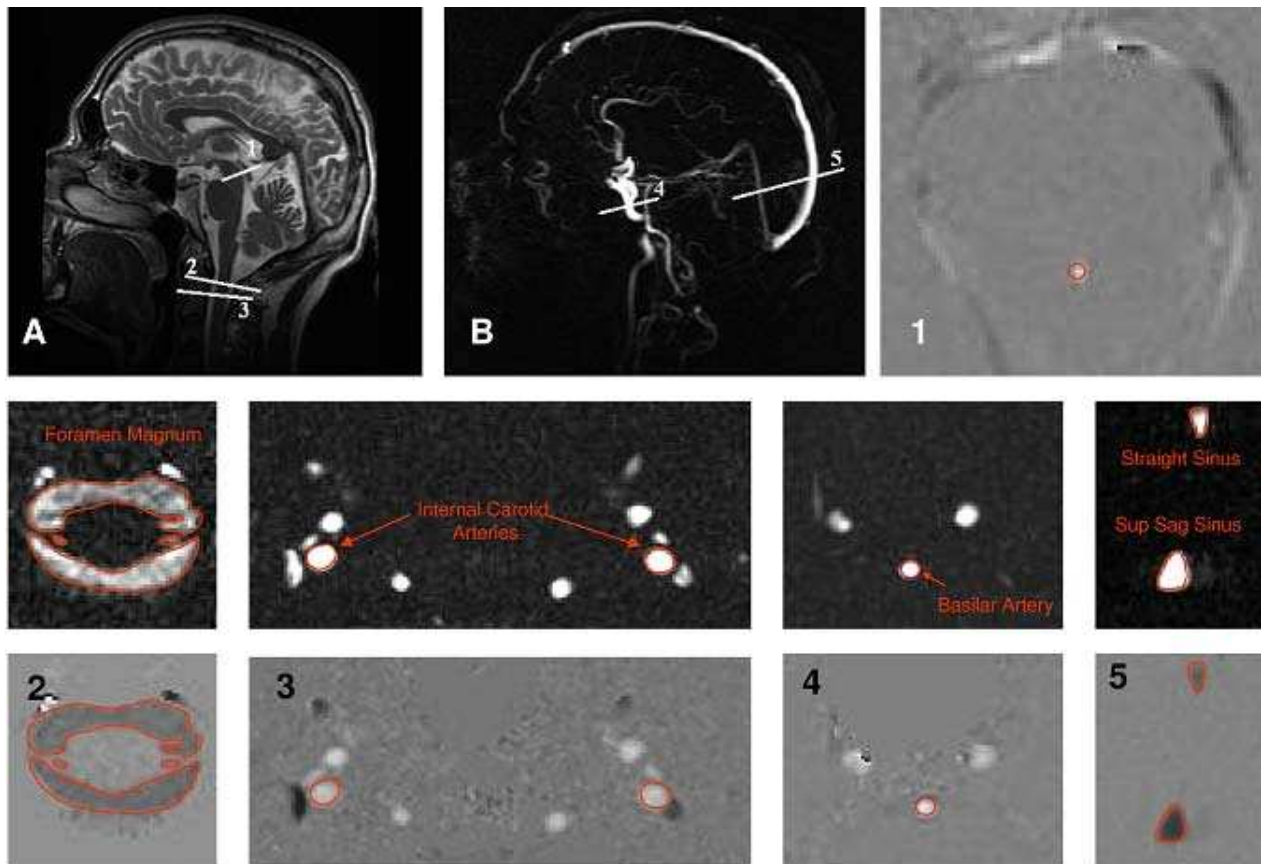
MR images. (a) Sagittal T1 scout image used to determine flow acquisition level and oblique axis for 1-AQ, 2-CA, 3-FM. (b) Phase contrast angiogram used to determine flow acquisition level for 4-BA, 5-SS. 1-5 Typical velocity encoded MR images of the vessels in which flows were measured. 1 AQ 2 FM 3 CA 4 BA 5 SS. The middle row shows corresponding modulus images
